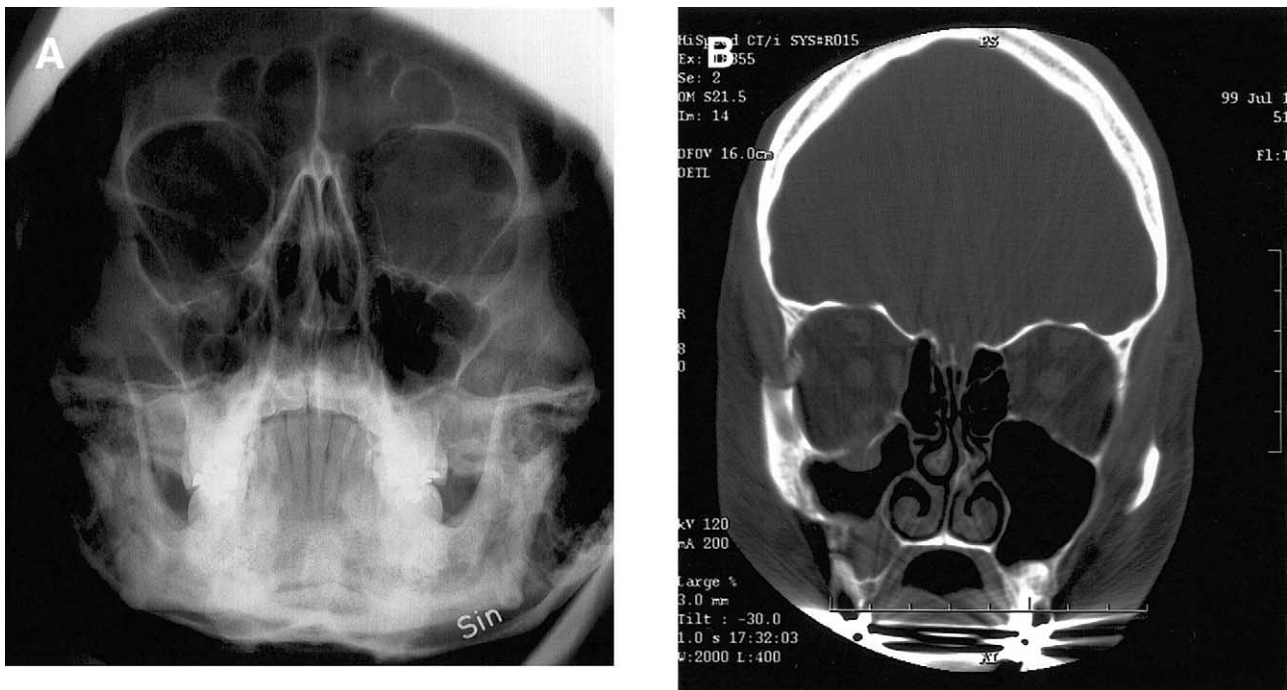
How often is an operation on the internal orbit performed unnecessarily? *A*, A plain radiograph showing a zygomatico-orbital fracture involving the right orbital floor (tetrapod zygomatic fracture). *B*, Radiography was supplemented with a CT scan indicating a possible herniation, but in retrospect was diagnosed as a hematoma in connection with the orbital floor. At surgery, when an orbital exploration was performed, it was verified that the floor was completely reduced and rigid after a Gillies procedure without fixation. The periorbital was intact, and there was no incarceration of soft tissue. The operation on the internal orbit could therefore be regarded as unnecessary.
